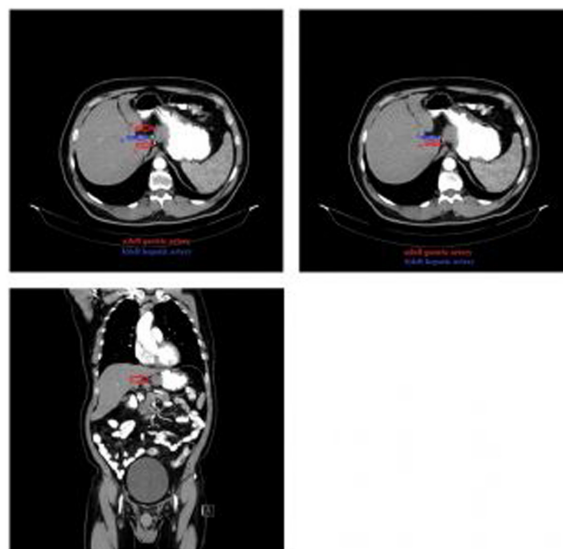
Oral and intravenous contrast-enhanced computed tomography imaging.
